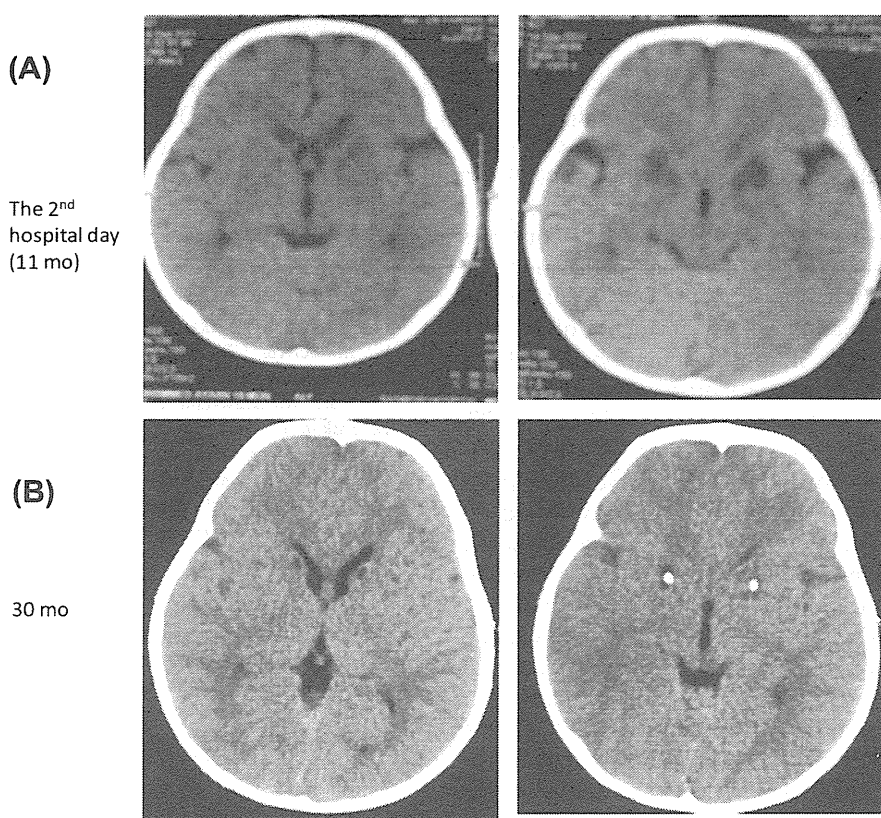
Brain CT findings in patient GK95. (A) Plain axial images show symmetrical hypodensities involving bilateral basal ganglia, suggestive of metabolic encephalopathy. (B) Plain axial images show bilateral symmetrical calcification involving the anterior part of the lentiform nucleus with surrounding low-density areas.
